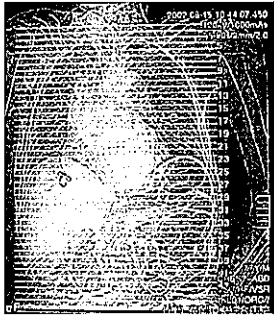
Autopsy imaging, CT slicing of chest
